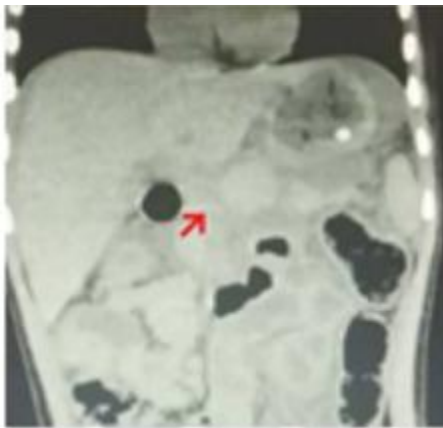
Contrast abdominal CT obtained from pancreatic laceration and hematoma in the suspicious pancreatic parenchyma body regarding the ductus pancreaticus with surrounding free fluid and found to be suspected of a faint laceration line in spleen with free fluid around it.
